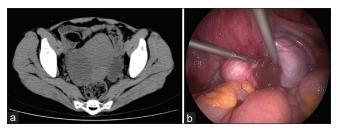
(a). Simple computed tomography image. Cysts are visible on both adnexa. The intestinal tract had mild edematous change and fluffing of the surrounding fat issue. (b). Intraoperative findings. Ovarian tumors are adhered to the broad ligaments on the posterior surface of uterus. The content fluid is brown
